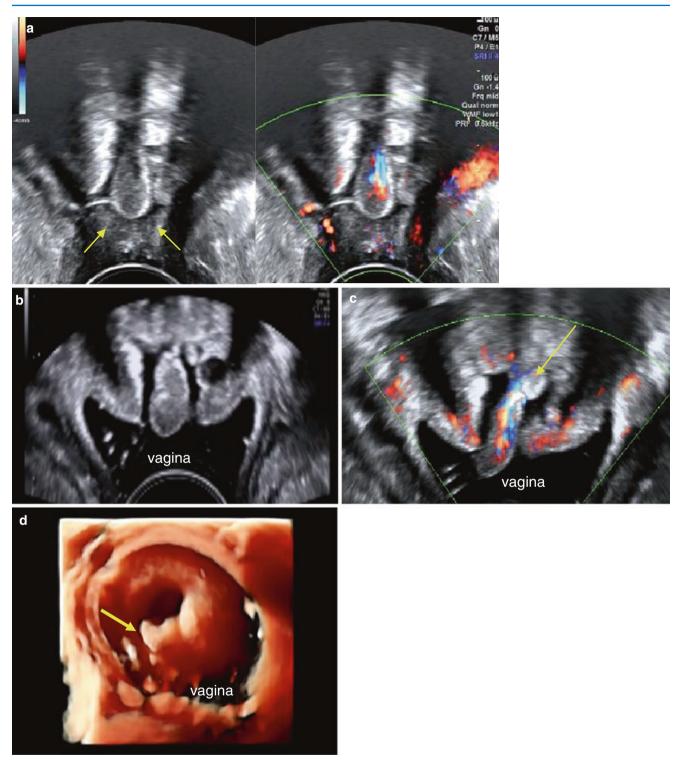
(a) Tear-shaped polyp seen in cervical canal on regular TVS – on greyscale and on colour Doppler. The vaginal walls (*arrows*) are seen just below the polyp opposing each other in the midline. (b–d) GSV – because of the intravaginal gel, the vaginal walls are seen apart and the lateral fornices are clearly visible. Gel is also seen surrounding the polyp. (b) Polyp on greyscale. (c) Polyp with feeder vessel approaching it from the cervical walls above. A smaller polyp (*arrow*) is seen close to its base. (d) 3D rendered image of the cervical os with the polyp (*arrow*) protruding out
